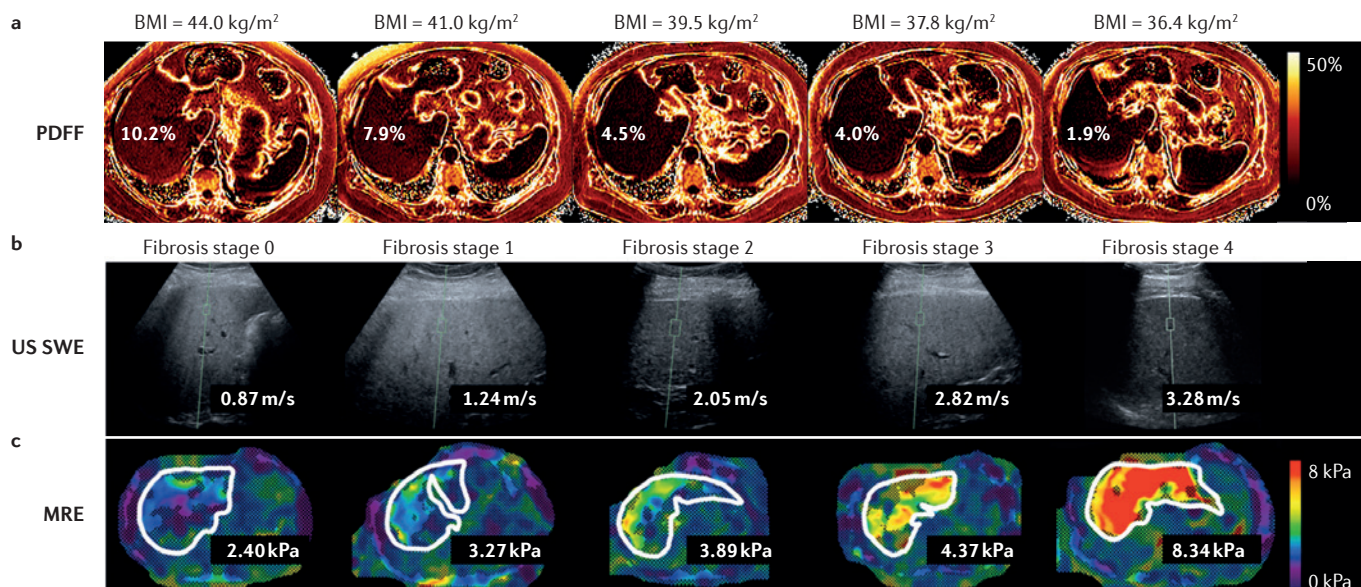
Diagnosis of liver fibrosis and NASH. Proton density fat fraction (PDFF) maps, obtained by MRI, of an obese woman at multiple time points during a weight loss programme. PDFF is reported as a percentage, with a biological range in humans from 1% to ~50%. Depending on the reference standard, a PDFF cut-off value of 3–6% differentiates non-steatotic from steatotic liver. Notice progressive reduction in PDFF with a reduction in body mass index (BMI; part a). Same-day ultrasound-based shear wave elastography (US SWE; part b) and magnetic resonance elastography (MRE; part c) in five adults with biopsy-proven nonalcoholic fatty liver disease (NAFLD) and fibrosis stages are shown. Notice that patients with NAFLD who also have more fibrosis have greater US SWE-measured shear wave speed and greater MRE-measured stiffness (magnitude of complex shear modulus) than patients who have less fibrosis.
